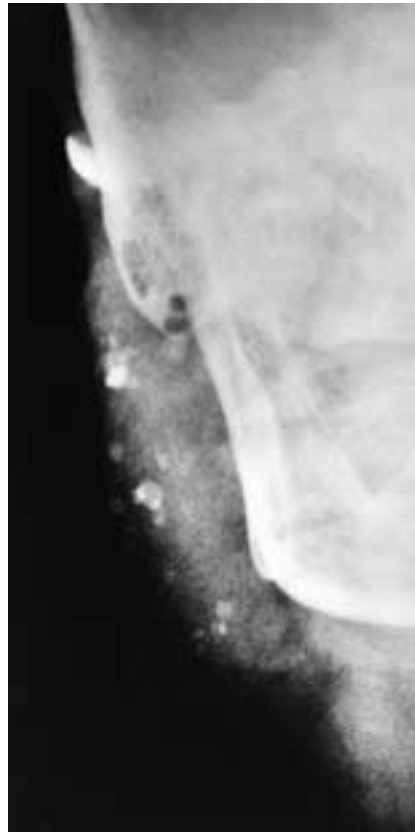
Frontal plain film of the parotid gland shows multiple calculi in a patient with chronic sialadenitis.
